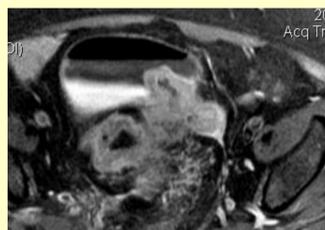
Contrast enhanced MRI scan of a patient with colon cancer, demonstrating a fistula between bladder and bowel.
